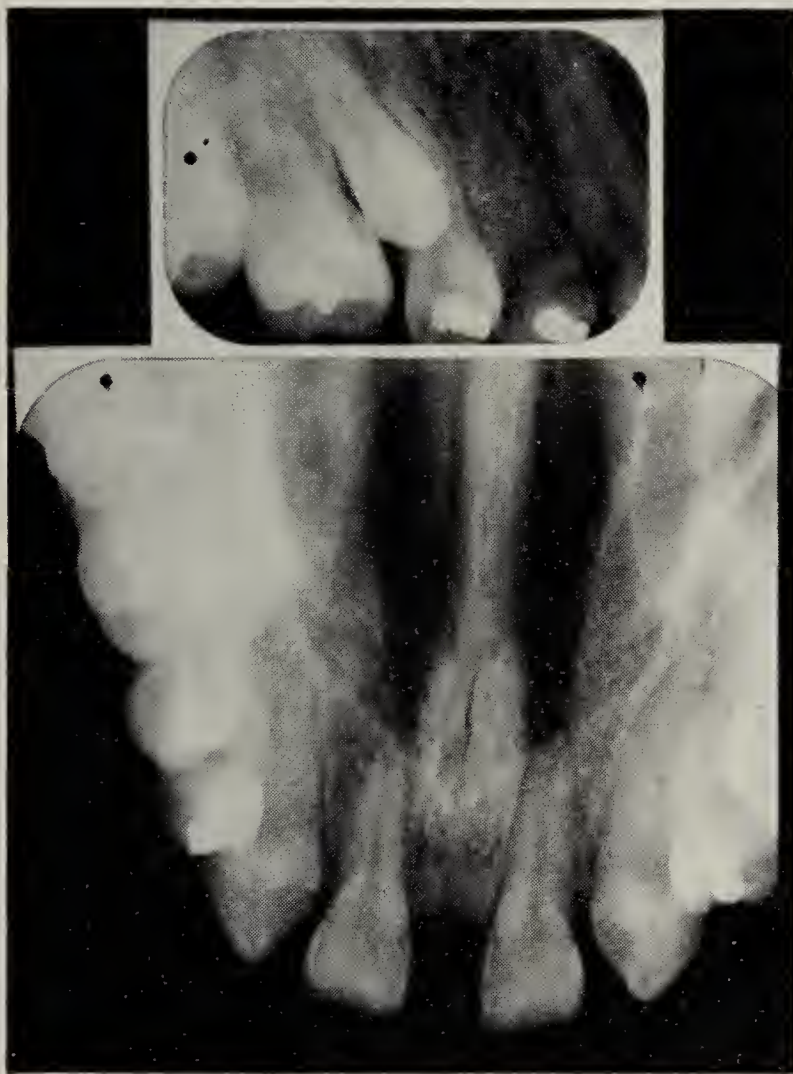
Intra-oral and occlusal radiograph.
